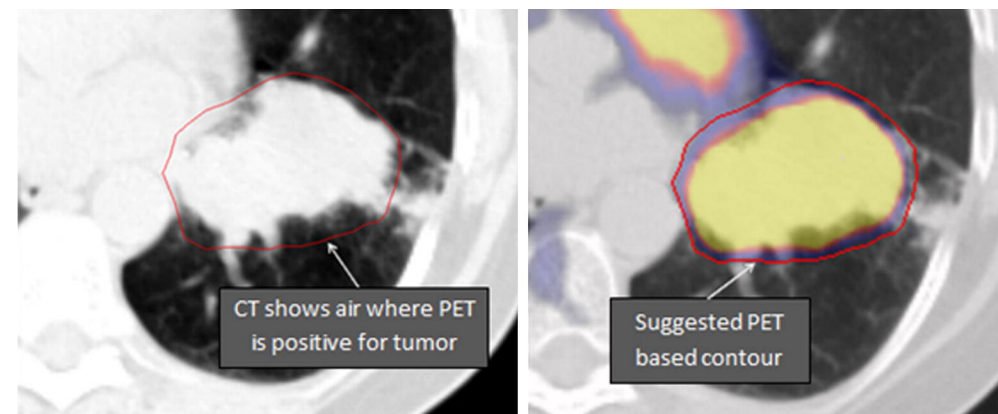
Example of a delineation of the reGTV based on PET in combination with a 3DCT. A primary tumor can be seen in the left upper lobe with high FDG uptake. The PET signal shows FDG uptake in air when the modalities are combined which is due to the movement of the tumor.
